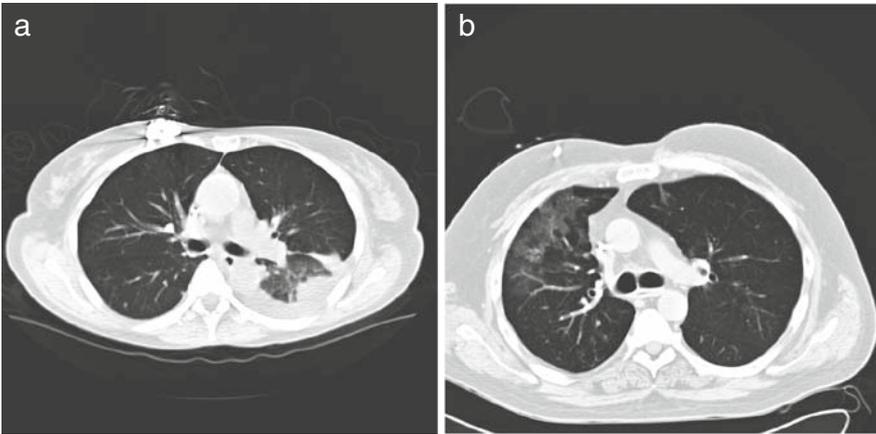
Progressive focal (A) and diffuse (B) radiographic pattern in patients with documented pulmonary aspergillosis on appropriate therapies. Both patients were late after allogeneic haematological stem cell transplantation, underwent bronchoscopy with evidence of alternate microbial diagnosis, and resolved clinically (and radiographically) without additional management
